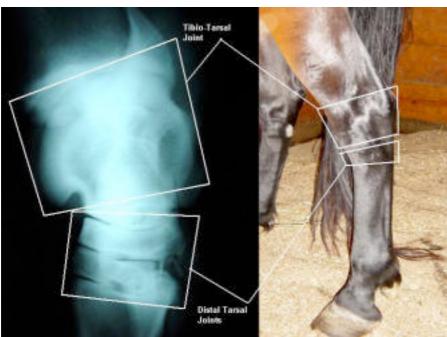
Lateral radiograph of a normal hock joint
